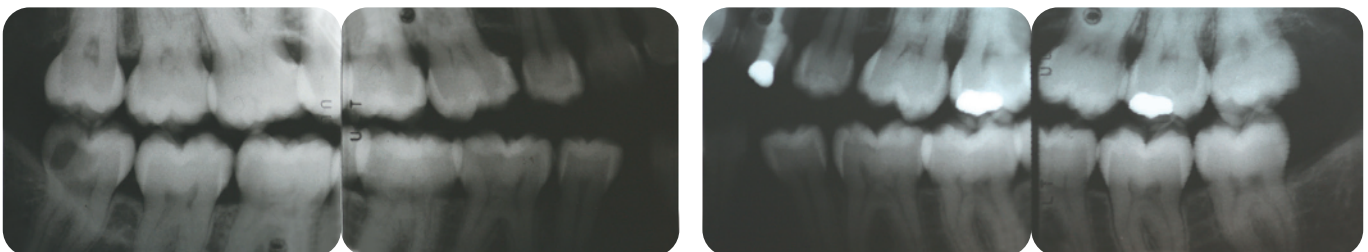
Bite-wing radiographs depicting the interproximal bone levels.
